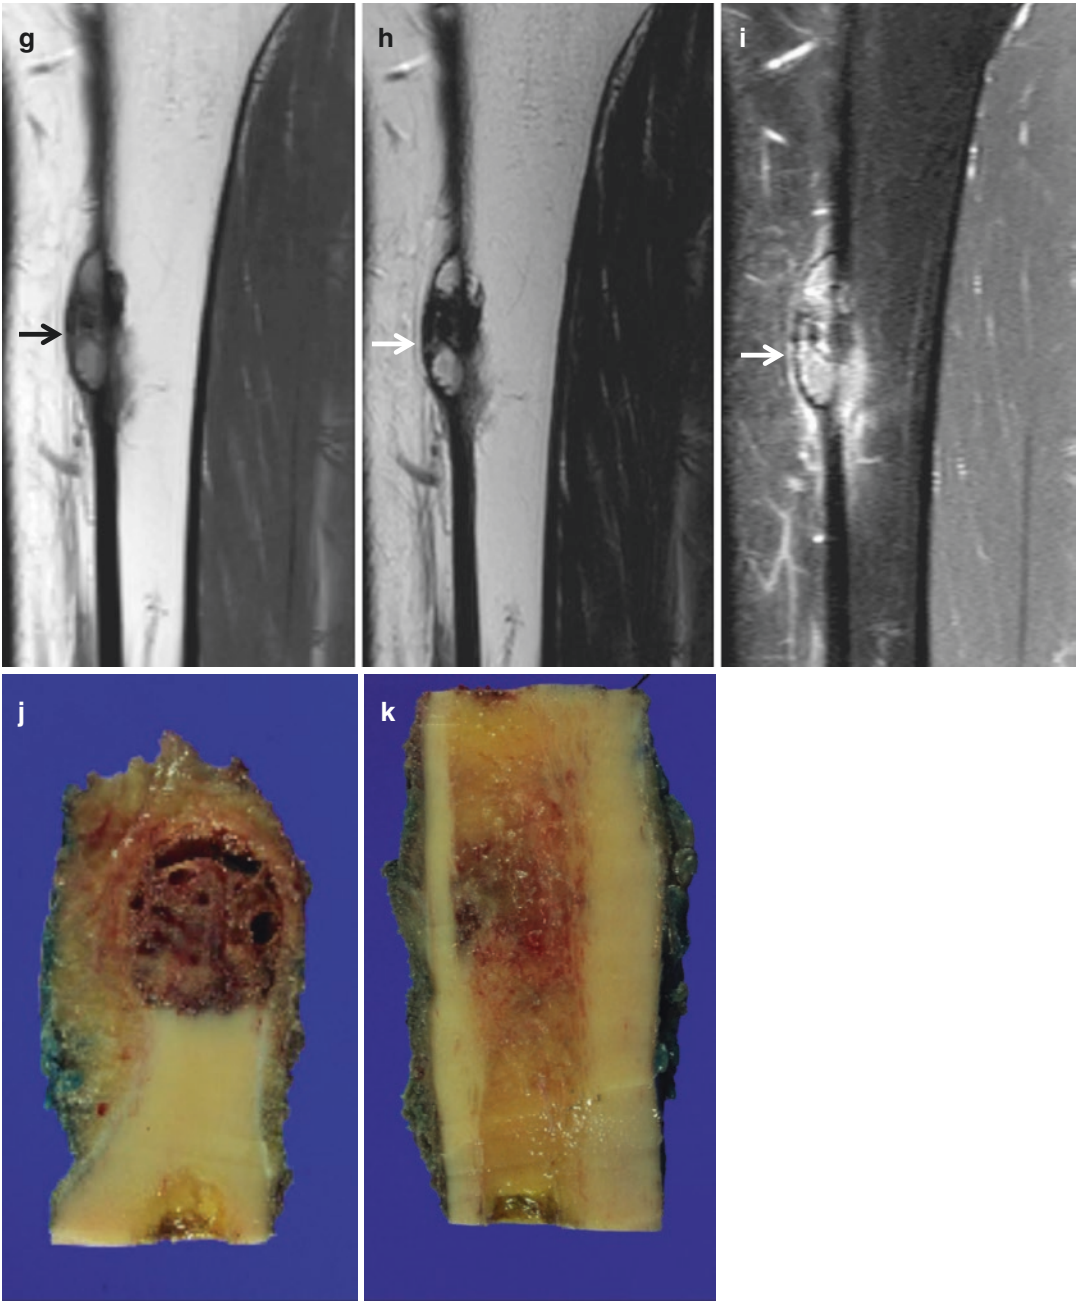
Periosteal osteosarcoma. (a) Anteroposterior radiograph of the left lower leg shows an osteolytic lesion with cortical scalloping and periosteal reaction (*arrow*) in the left tibia. (b) Lateral radiograph of the left lower leg again demonstrates an osteolytic lesion (*arrow*). (c) Bone scan shows a focal increased uptake (*arrow*) in the left tibia. (d) Axial T1-weighted MR image demonstrates a juxtacortical mass with intramedullary extension (*arrow*). (e) Axial fat-suppressed T2-weighted MR image demonstrates a heterogeneous signal intensity (*arrow*) of the lesion. (f) Axial fat-suppressed contrast-enhanced
